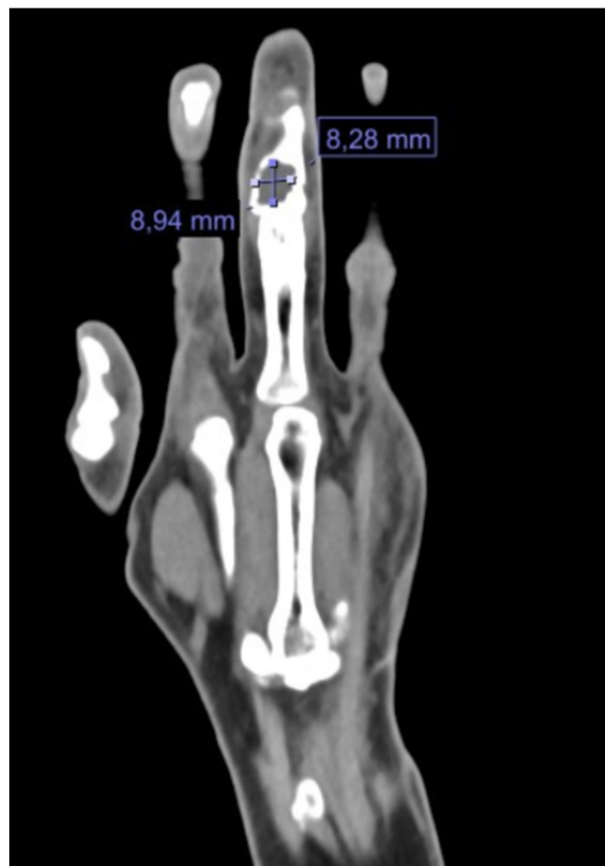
CT scan of the left hand coronal section. Hypodense oval lesion (8.9 x 8.2 mm)
